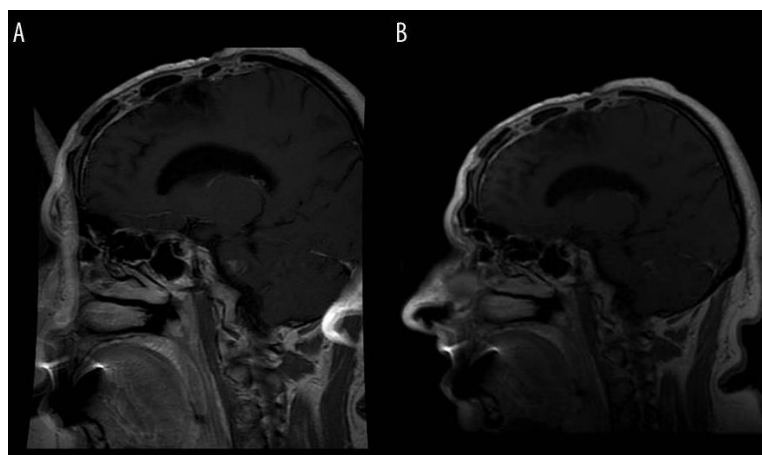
Aliasing artifact on brain MRI with FOV=24×18 cm (A). Same patient with FOV=24×24 cm (B) [259].
